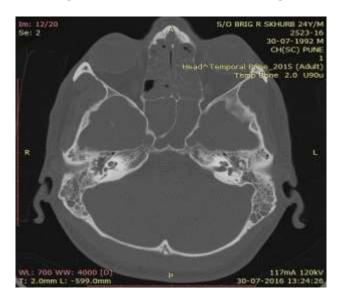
CT scan showing soft tissue attenuation in middle ear and mastoid.
